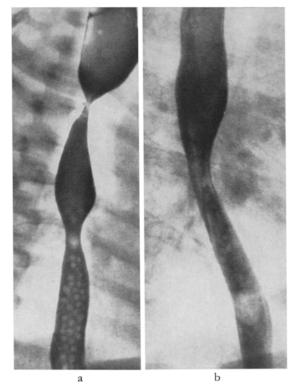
Roentgen examination of the oesophagus 2 weeks after operation for oesophageal atresia and tracheo-oesophageal fistula. The oedematous swelling at the site of the anastomosis causes hindrance to passage of the contrast medium. The stenosis at the level of the left atrium also causes some difficulties in passage
